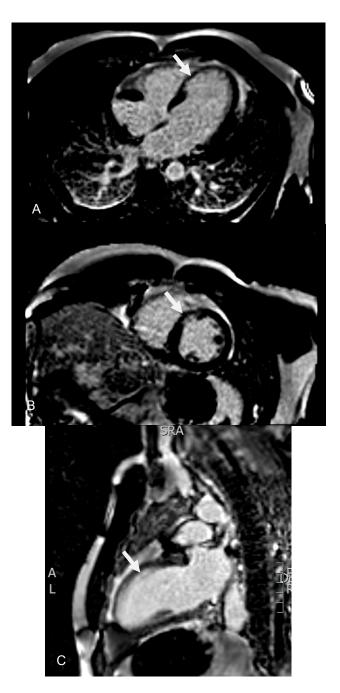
Cardiac MRI demonstrating late-gadolinium enhancement and wall thinning in the mid to apical anteroseptal wall (white arrows) visualized in the 4-chamber (A), short axis (B), and 2-chamber (C) projections
